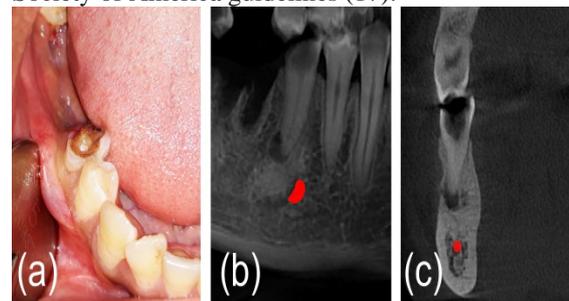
shows a presentation of a case with a periapical granuloma related to lower right second premolar preoperatively.
